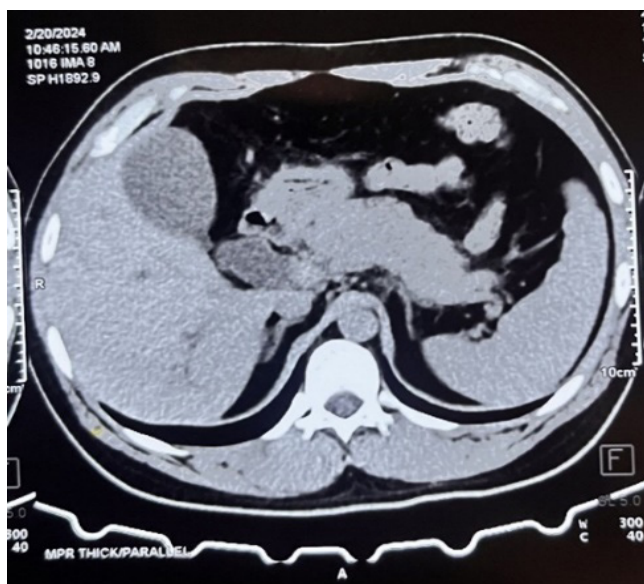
CT scan showing enlarged pancreas
